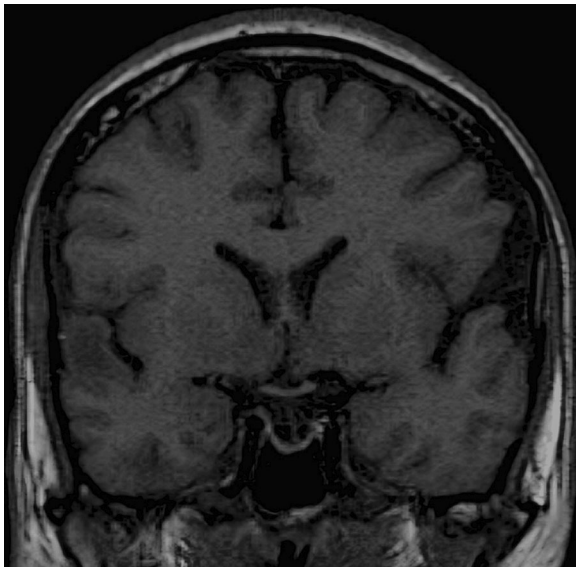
Magnetic resonance imaging (MRI) scan revealing T1-weighted images without contrast, indicating a small, low-intensity area in the right temporal region
